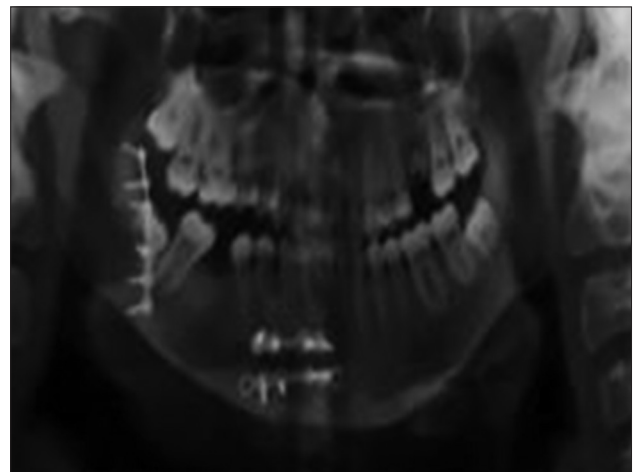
6 months orthopantomogram
